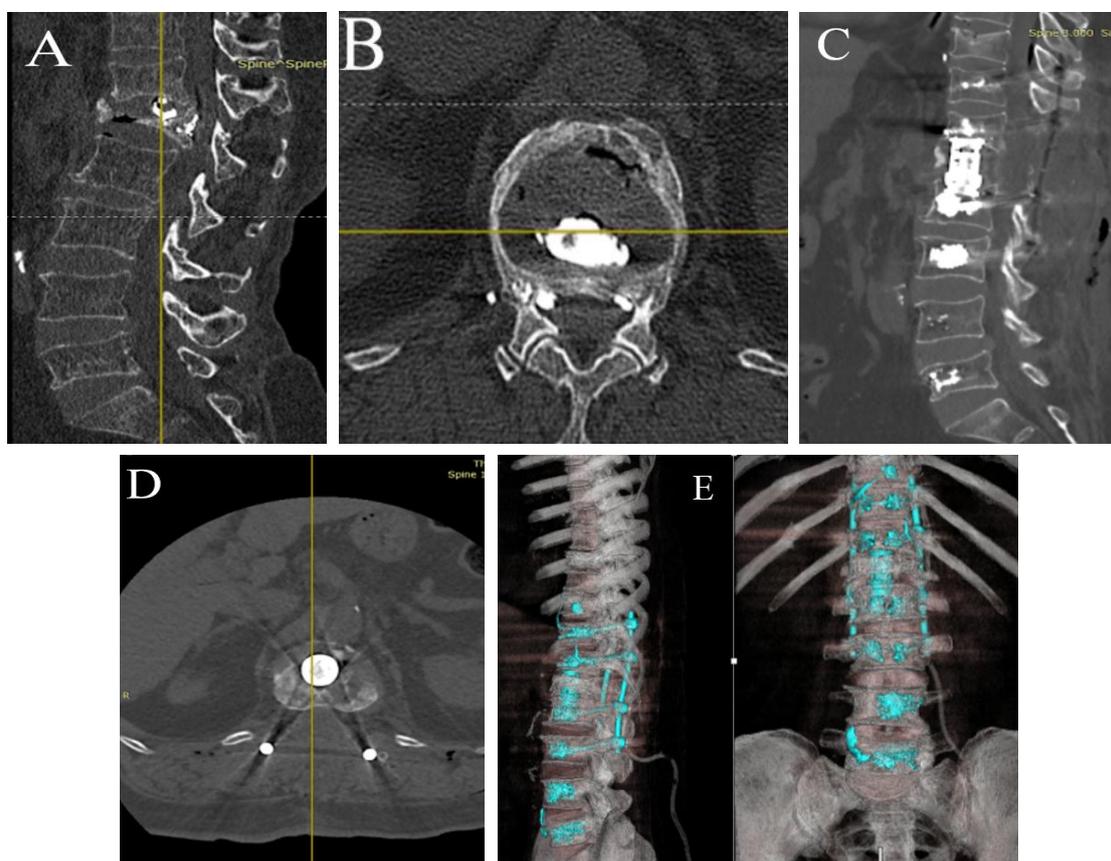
Preoperative CT scans of a patient with a pathological vertebral fracture due to osteoporosis in the remote period after vertebroplasty (A, B). Postoperative CT scans obtained on day 2 following revision surgery (C, D, E). (Image from the author’s personal archive)
